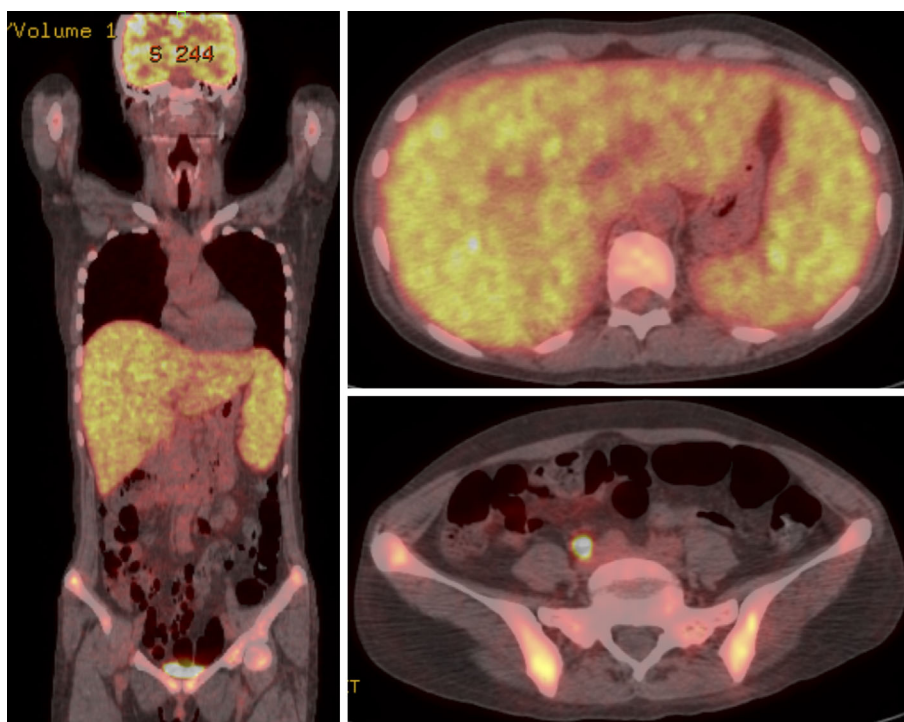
A positron emission tomography-computed tomography scan showing hepatosplenomegaly and abnormal fluorodeoxyglucose accumulation in the liver, spleen, and bones without systemic lymphadenopathy.
